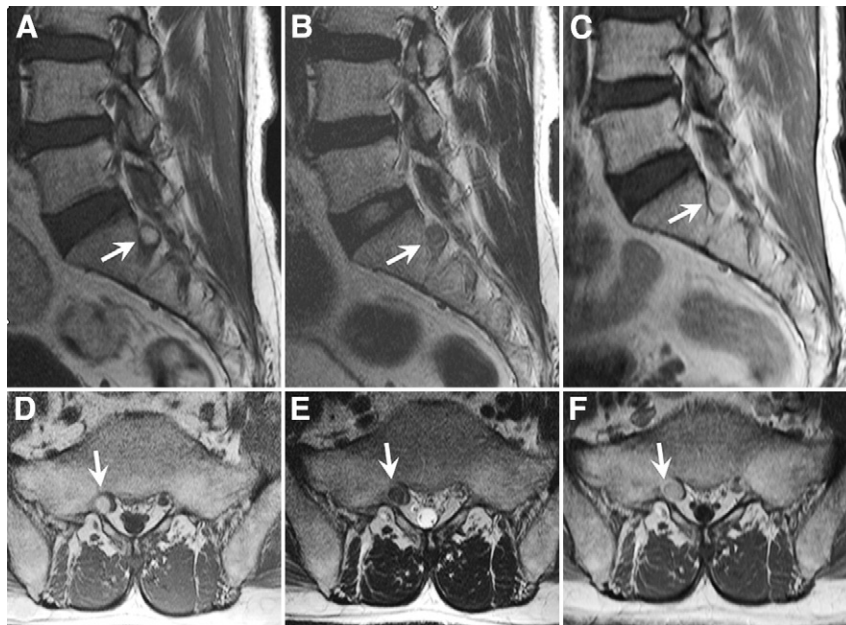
T1 (A, D), T2 (B, E), and contrast-enhanced T1 (C, F) sagittal and axial MRI show 1-cm-size mass (white arrow) around the right S-1 root.
